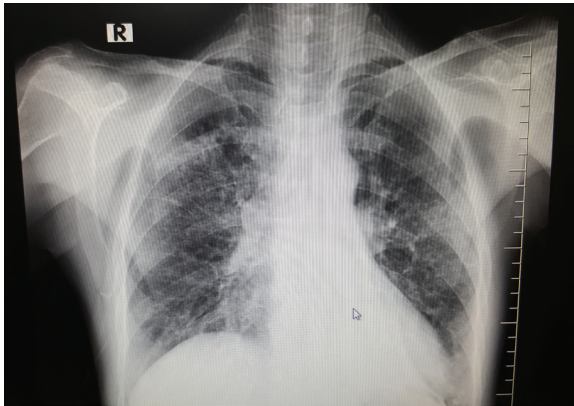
A routine chest x-ray still showed a double cardiac contour suggestive left lower collapse.
